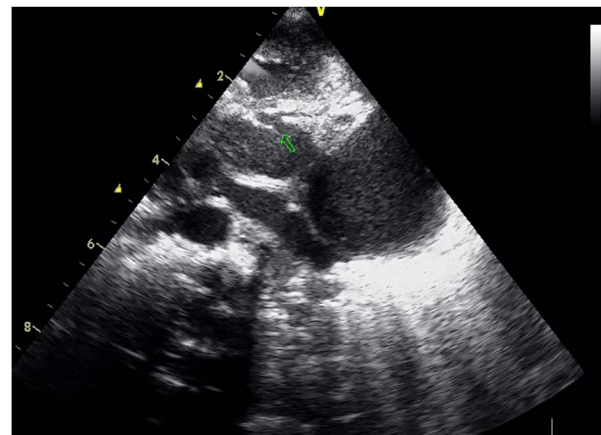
Transthoracic echocardiography image of tortuous tunnel arose from inside left sinus valsalva, separate from the origin of coronary artery, passed posterior to the aorta, and opened into the right atrium just above coronary sinus. Opening part was shown with arrow*
